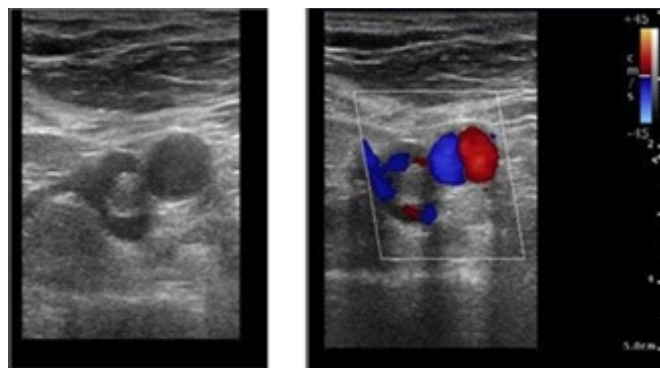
Color Doppler mode shows along with a normal common femoral artery, diabetes patients have partial, chronic thrombosis of the common femoral vein (CFV) [10]
